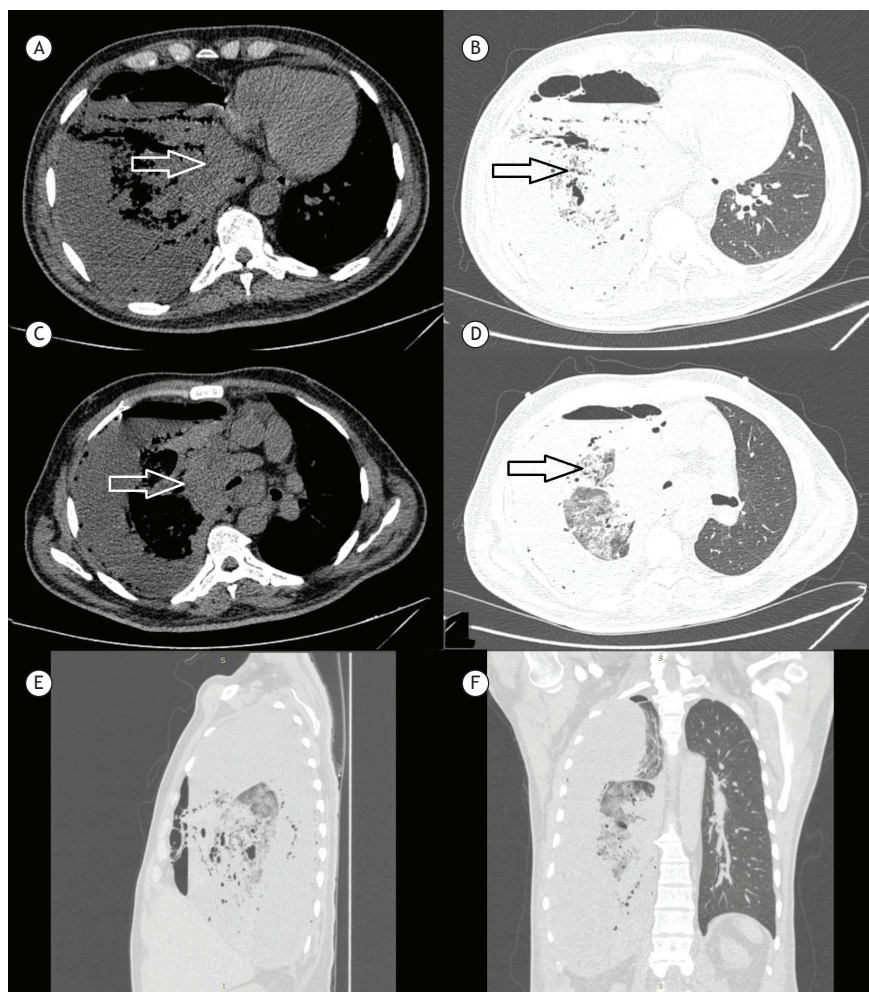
CT scans of the chest, showing massive hydropneumothorax in the right lung, with almost total restrictive atelectasis (A through F). Note the perihilar mass affecting the middle and lower lobes of the right lung (white arrow in A and C). In the remaining parenchyma of the right lung, there are consolidations with air bronchograms and bronchiectasis, accompanied by ground-glass opacities, suggestive of an inflammatory/infectious process (black arrow in B and D).
